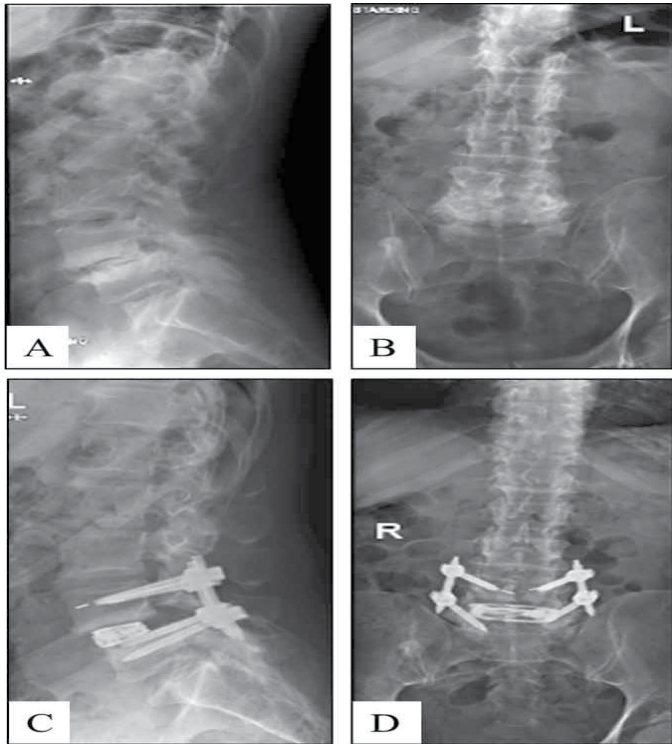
Preoperative lateral (A) and anteroposterior (B) radiographs and postoperative lateral (C) and anteroposterior (D) radiographs of a one-level MIS LLIF using an adjustable lordotic expandable interbody spacer at L4-L5.
